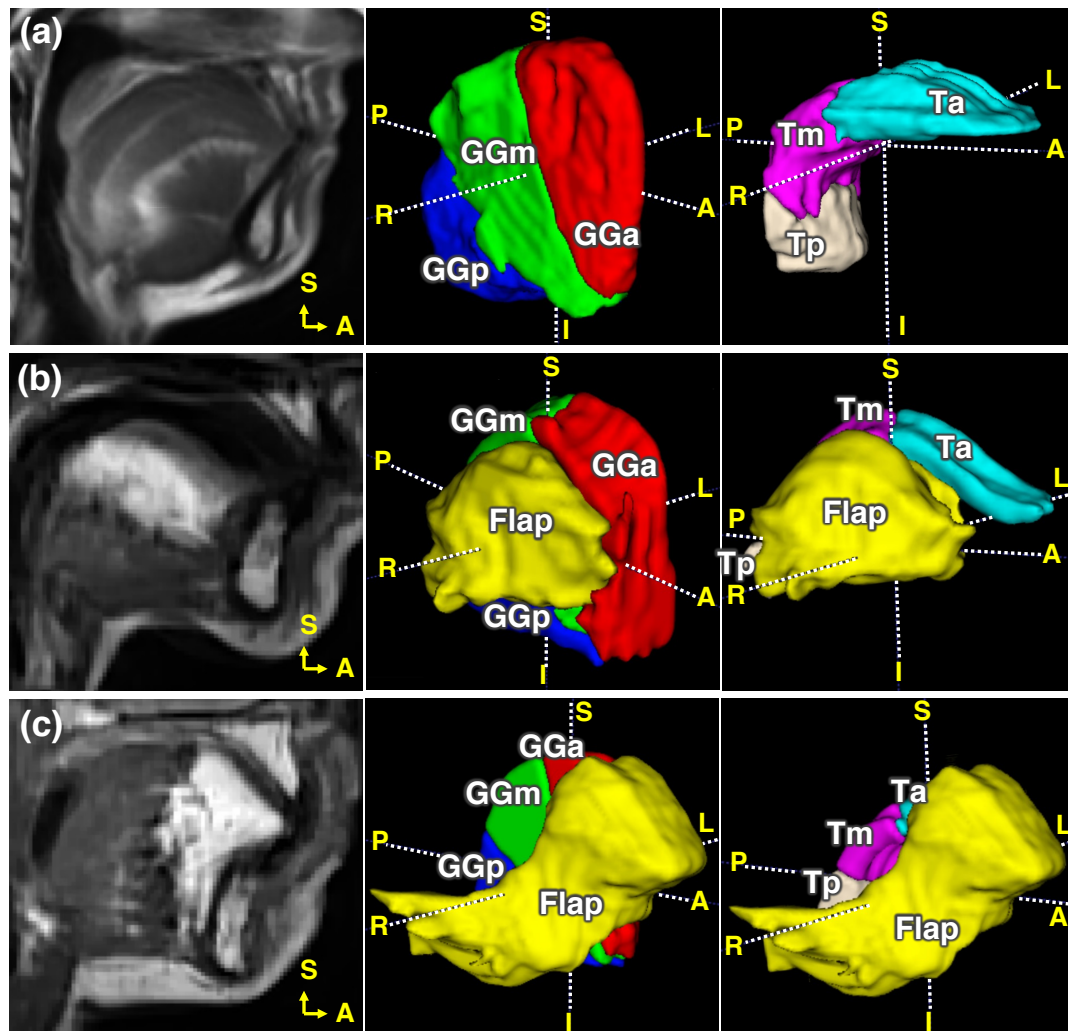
High-resolution T2-w MR images and the manual labeling of the genioglossus (GG) and transverse (T) muscles using the T2-w images. The two muscles are subdivided into anterior (a), middle (m), and posterior (p) parts. In each row, the left subfigure shows a sagittal slice of the T2-w MR image. The middle and right subfigures show 3D rendering of the GG and T muscles, respectively. Flap region is also shown in the patients. (a): Manual labeling of the muscles on the T2-w MR image atlas. (b) and (c): Manual labeling of the muscles and flap on the two glossectomy patients P1 and P2, respectively. S = superior; I = inferior; A = anterior; P = posterior; R = right; L = left.
